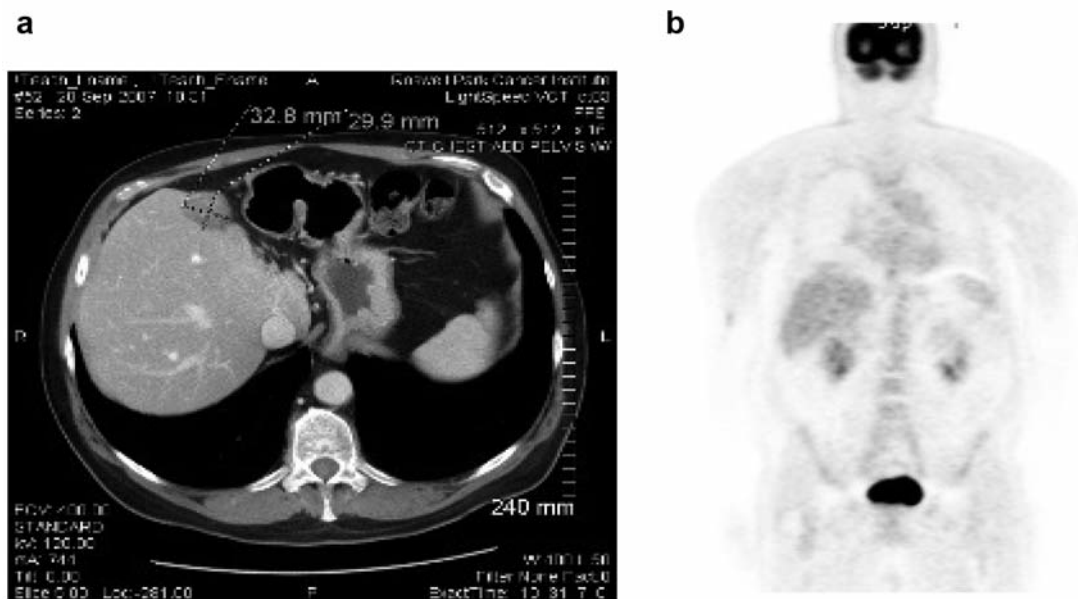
CT (a) and PET (b) scans showing shrinkage of liver mass and resolution of left scapular metastasis after chemotherapy and prior to hepatectomy.
